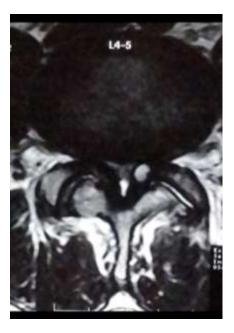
MRI showing L4 –L5 synovial cyst
